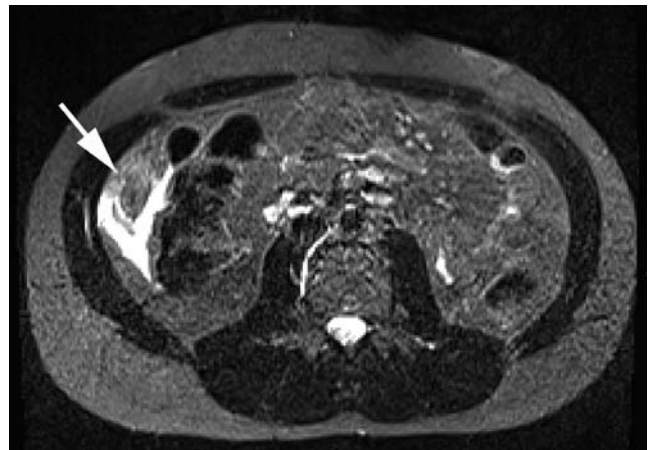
Axial STIR image from MRI. Omental infarct with surrounding inflammation and fluid (arrow).
